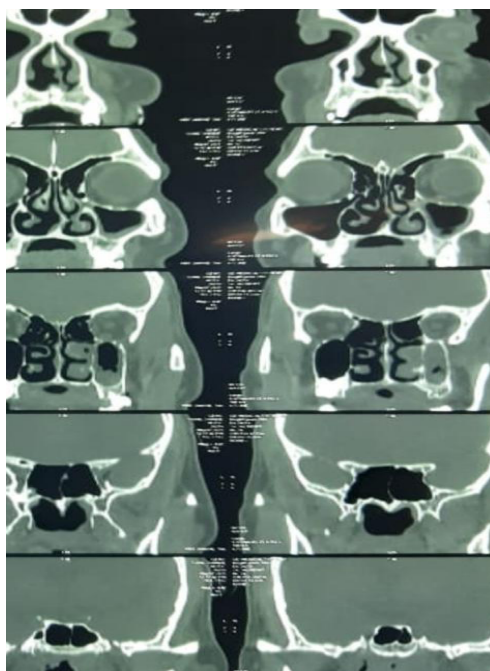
CT picture, early maxillary sinus mucosal disease
